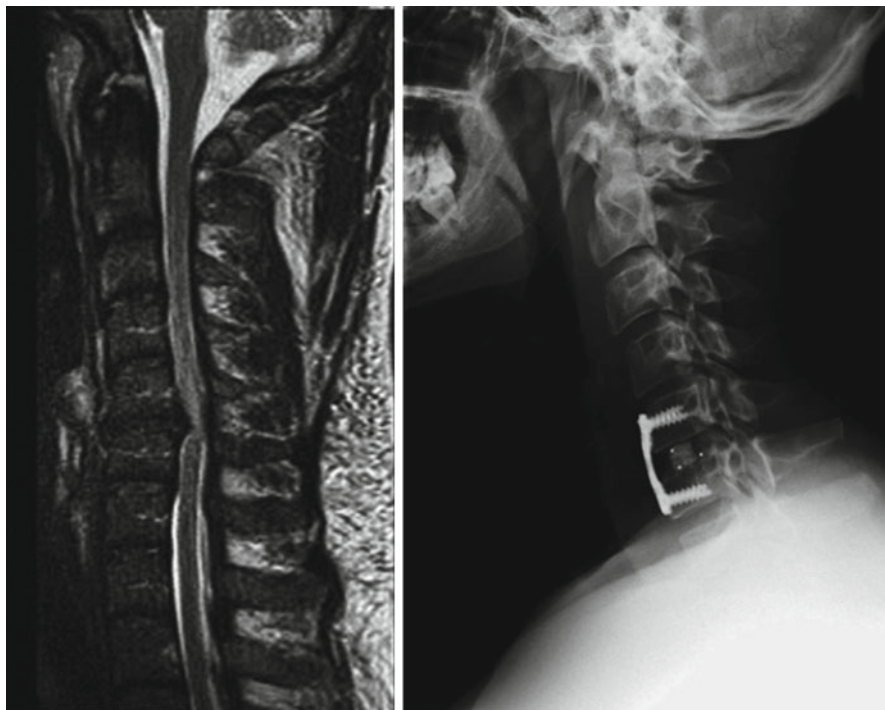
Radiographs showing C5/C6 disc prolapse treated by C5/C6 curettage and fusion (Courtesy of Dilip Malhotra, Bahrain. Reproduced with kind permission of Springer Verlag)
